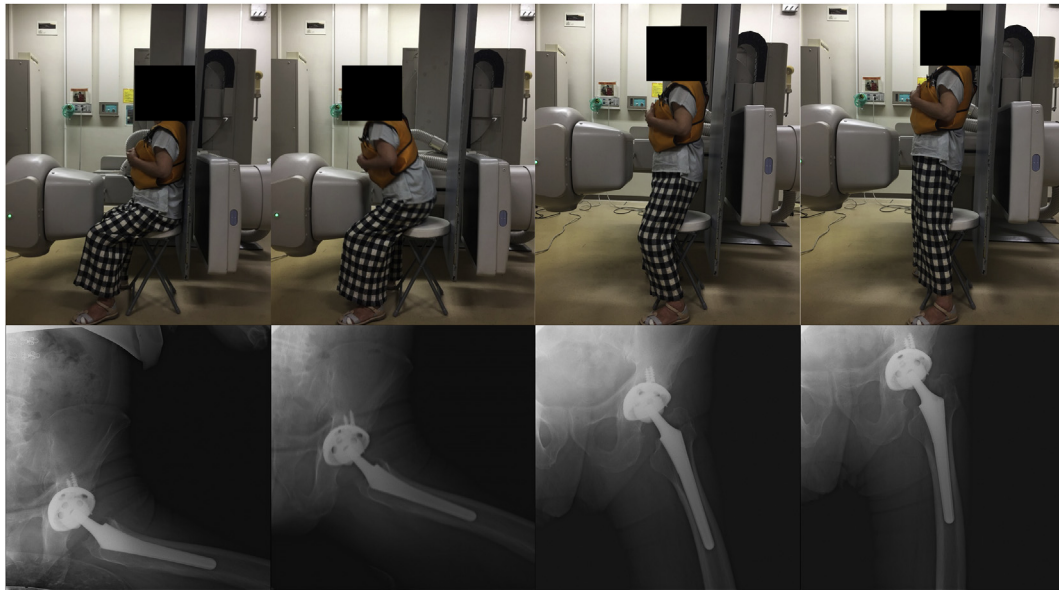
Each subject rose from the chair with a height of 46.5 cm, and their hip motion was observed using a flat-panel X-ray detector.
